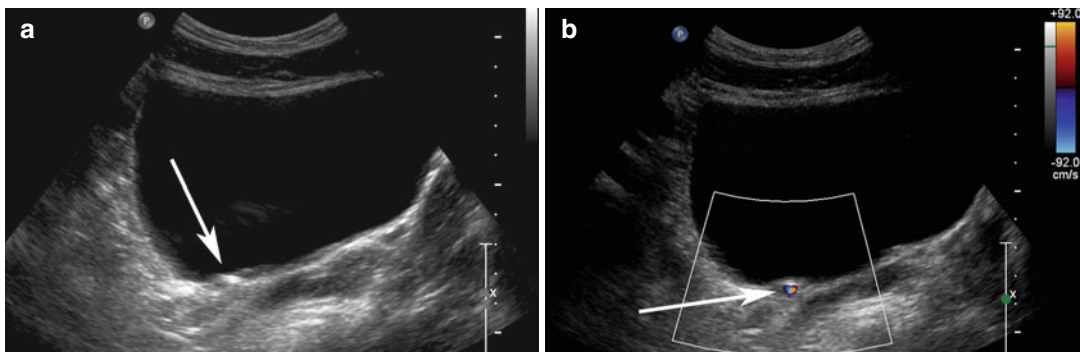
(a) Transverse ultrasound image of the bladder shows an echogenic structure at the right UVJ (arrow) which could represent a calculus, but there is no definite shadowing behind it. (b) When color Doppler is turned on
